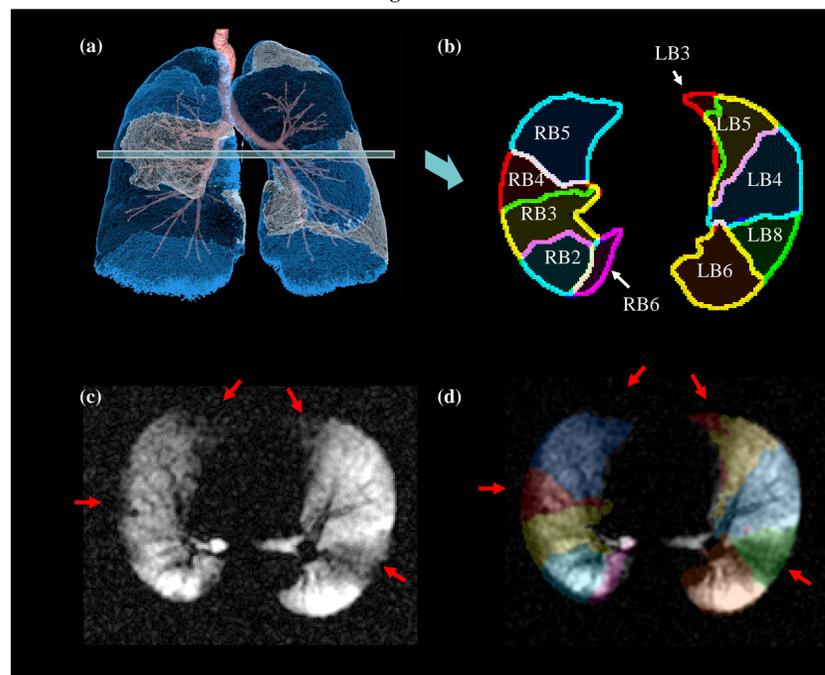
Identification of segmental volumes on CT in (a) allows for axial segment mask shown in (b) [3]. This mask can be overlaid on HP ³He MRI image (c) to identify spatial distribution of ventilation defects and calculate segmental VDP (SVDP). RB2-3 are segments of RUL, RB4-5 of RML, and RB6 of RLL; LB3-5 are segments of LUL, LB6 and LB8 of LLL. Note spatial overlap of prominent ventilation defect (red arrows) with segment LB8.
